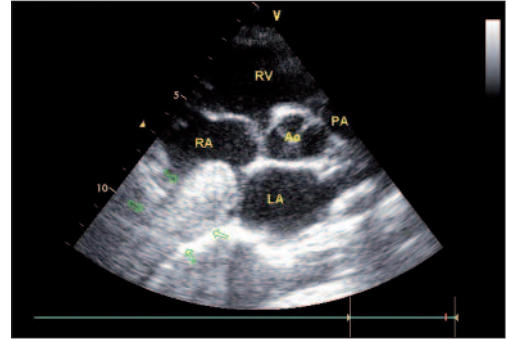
Parasternal short axis image is excellently showing the tumor thrombus filling whole inferior vena cava and protruding into the right atrium. Note that borders of mass can easily distinguished from caval walls (arrows).
